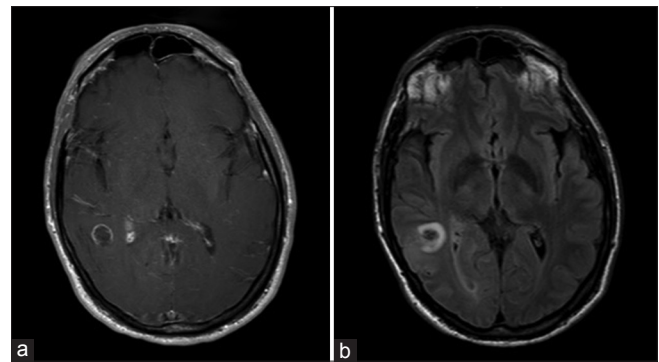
Axial cut MR showing right, posterior temporal cystic lesion measuring 1.5×1.5 cm with incomplete peripheral enhancement on T1 contrast-enhanced image (a) with mild surrounding vasogenic edema on T2 FLAIR (b)
